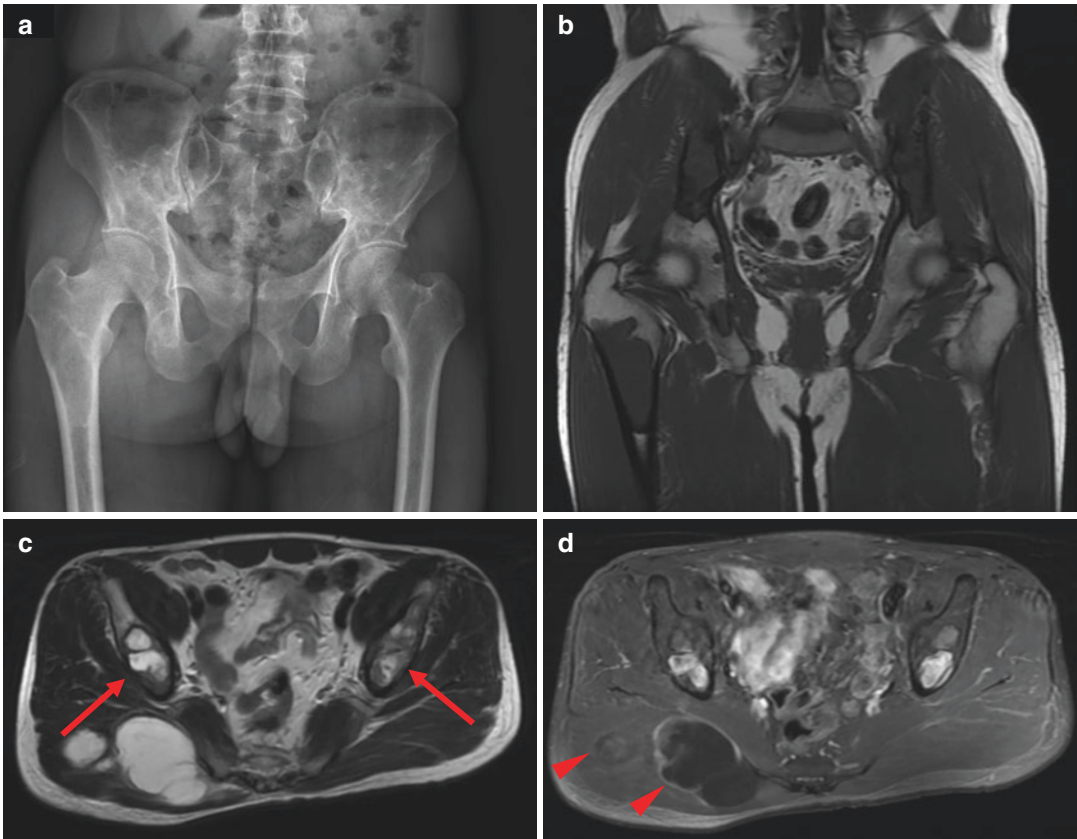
Mazabraud syndrome. AP radiograph of the pelvis (a) reveals multifocal osteolytic lesions with thin sclerotic margins involving the ilium and the right femur, in keeping with polyostotic fibrous dysplasia. On coronal T1WI (b), the corresponding bone lesions appear to be
